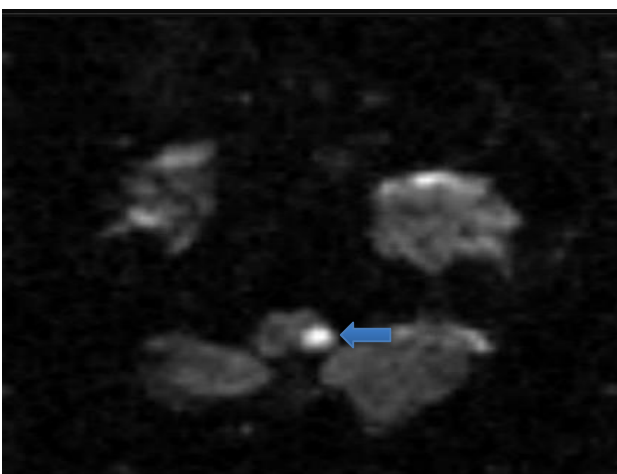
DWI shows diffusion restriction in left medulla.
